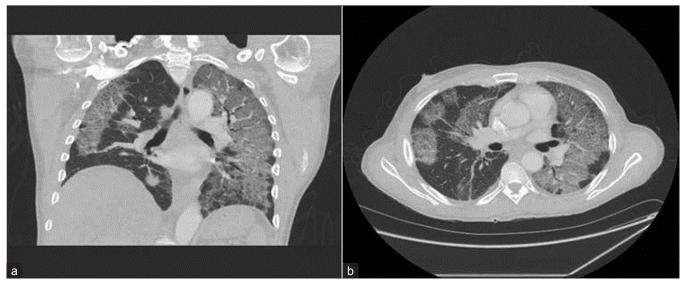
(a-b) Computed tomography scan of the chest at the time of admission
